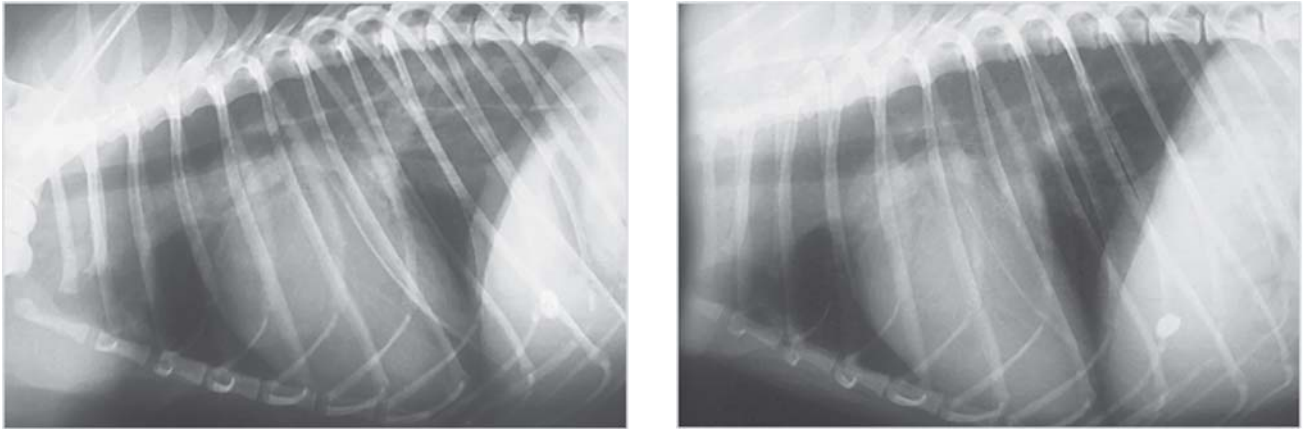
Right lateral radiographic of a patient before (a) and after (b) treatment with pimobendan. Observe oedema in the perihilar zone and dorsal aspect of the lungs in the first figure but none after treatment
